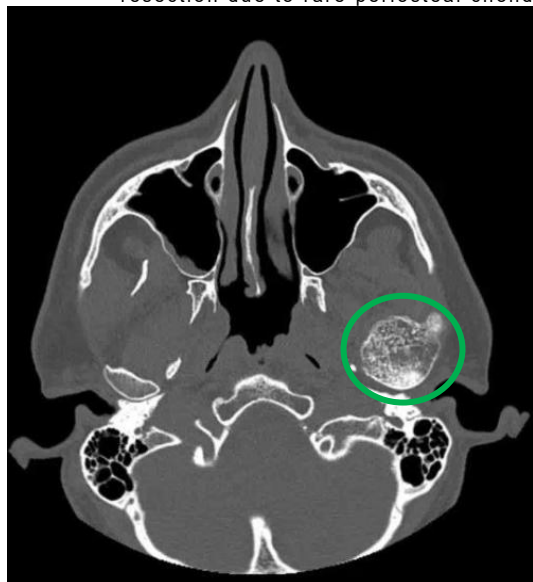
Computed tomography, axial view. Proliferative lesion of the left TMJ inside the green circle (RadiAnt DICOM Viewer 2025.2).
